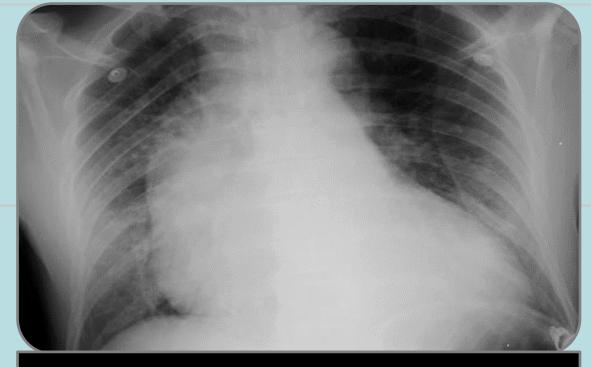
Chest Radiograph showing widen mediastinum
